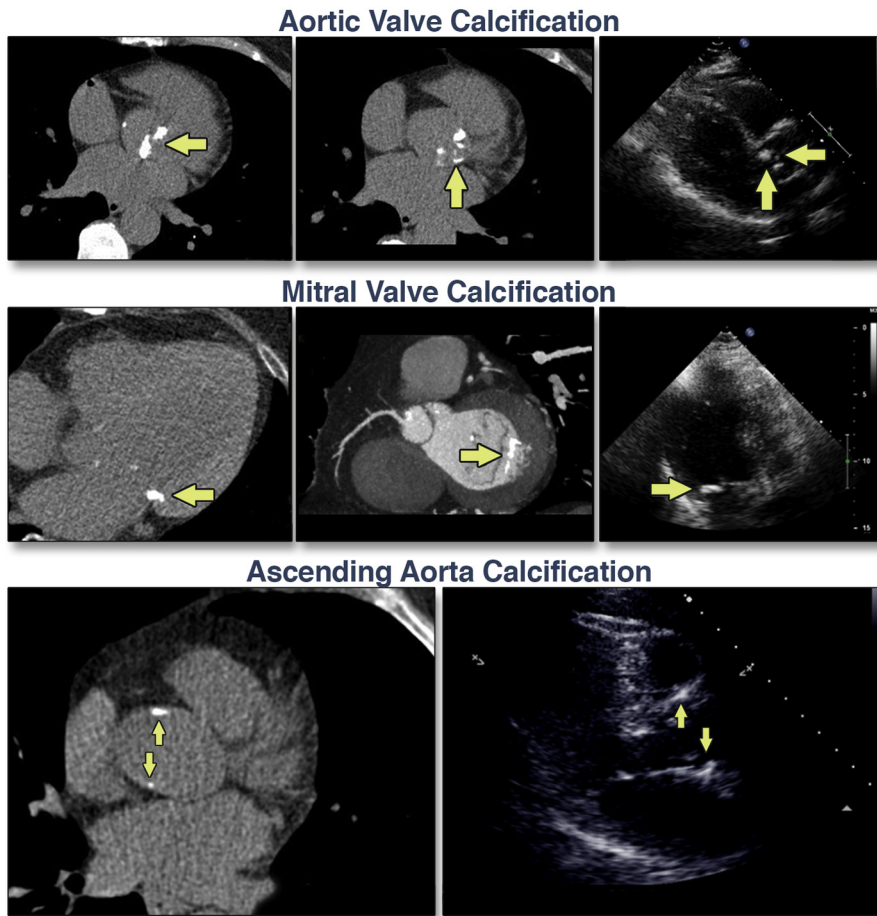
Example of Calcifications Imaged in Parallel by Echocardiography and Cardiac Computed Tomography
